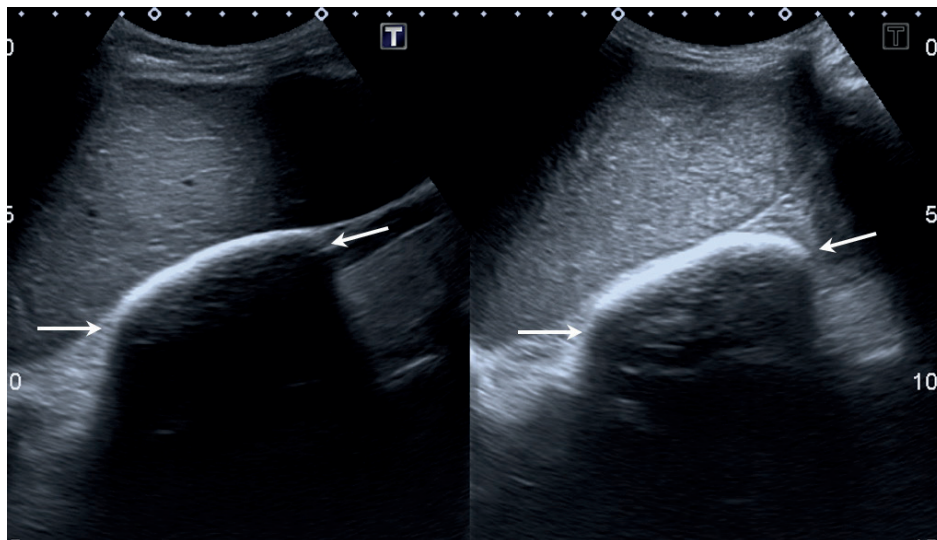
Ultrasound of kidneys showing completely calcified, shrunken organs with no internal anatomy visible (arrows).
